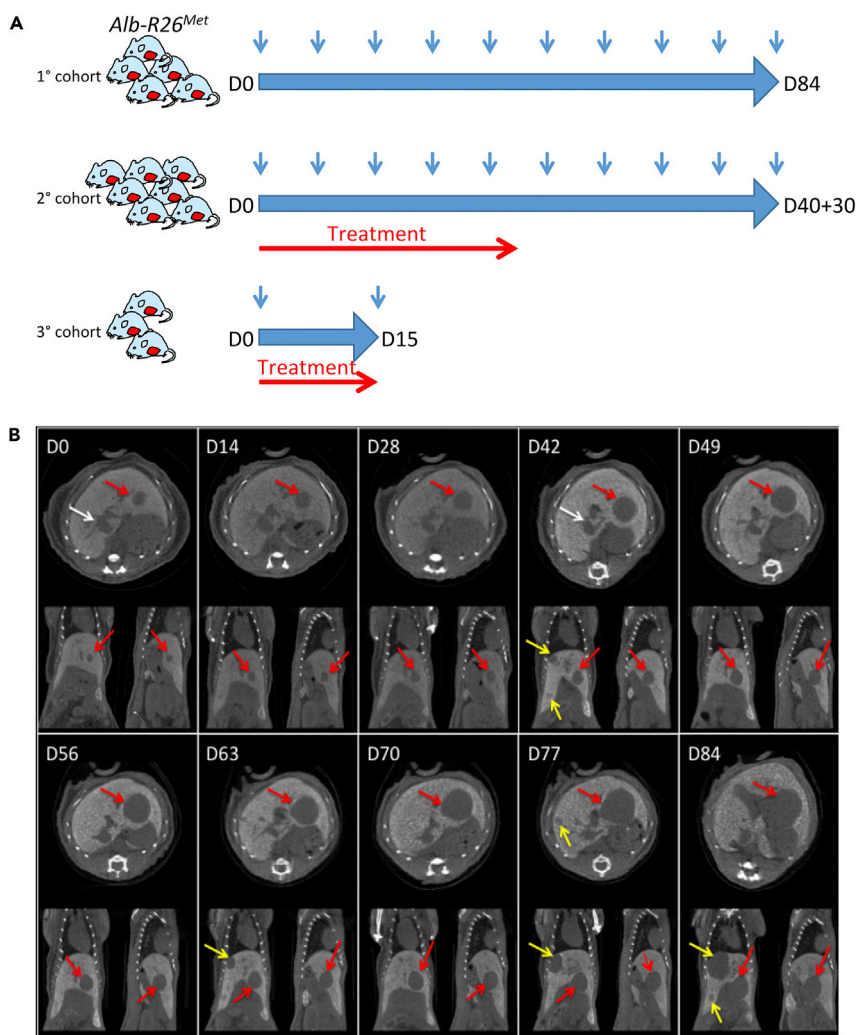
Longitudinal *In Vivo* PC-CT Imaging of Spontaneous Liver Tumor Dynamics in the *Alb-R26^{Met}* Model
